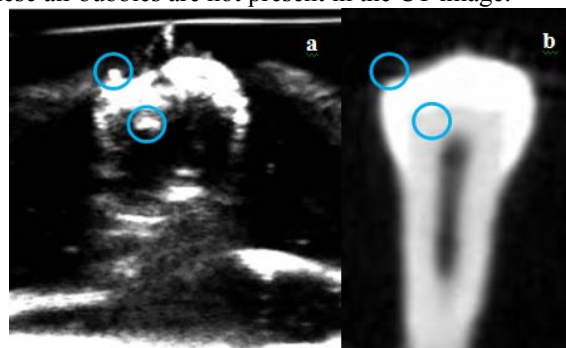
Comparison between a processed ultrasound image and the corresponding CT image. (a) Possible air bubbles trapped in the gelatin are noted in the ultrasound image, (b) which were absent in the CT image.
